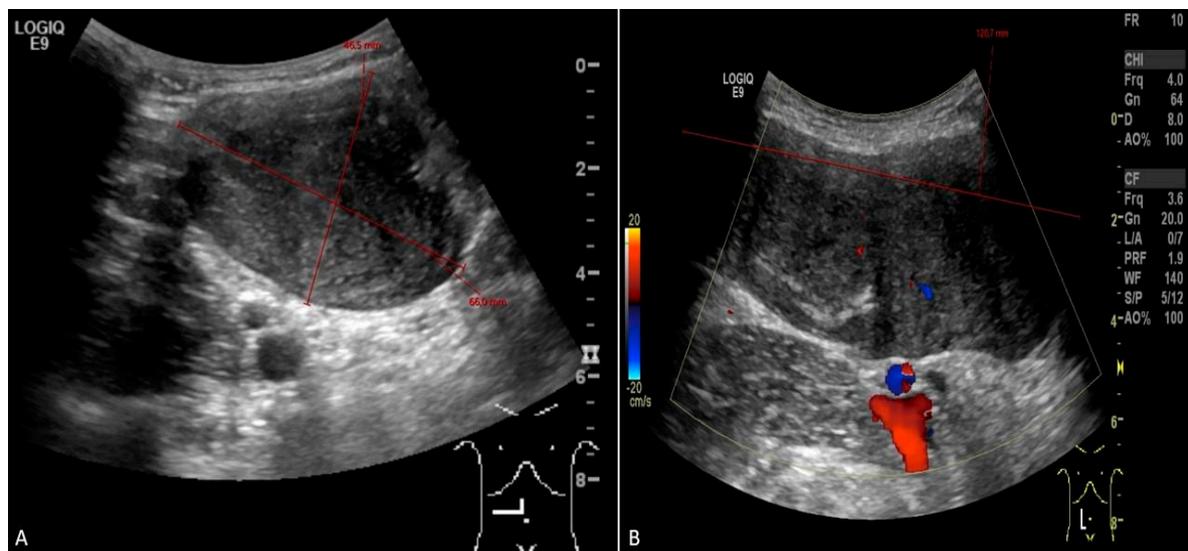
Abdominal ultrasound (A – transverse view; B – longitudinal view) picture of desmoid tumor sized 12 x 4.6 x 6.6 cm on the first diagnosis.
